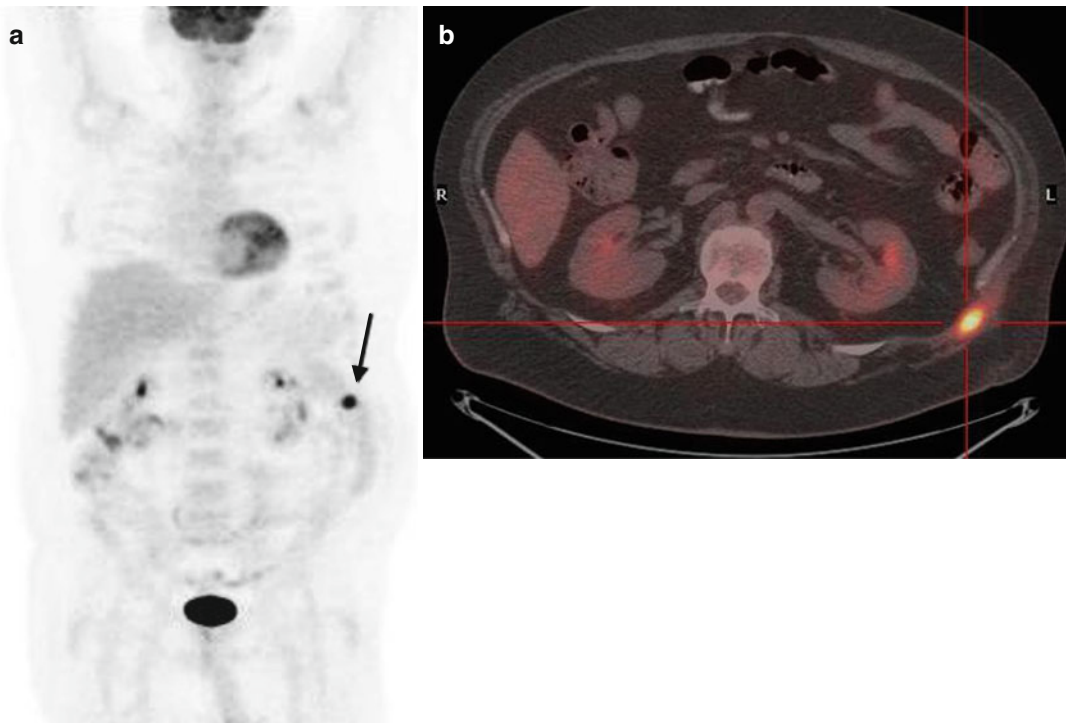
(a, b) MIP-PET and fused PET/CT – end of treatment: Highly hypermetabolic (SUVmax of 18.5) residual lesion in the left posterolateral thoracic wall between the 11th and 12th rib (arrow in the MIP image)
